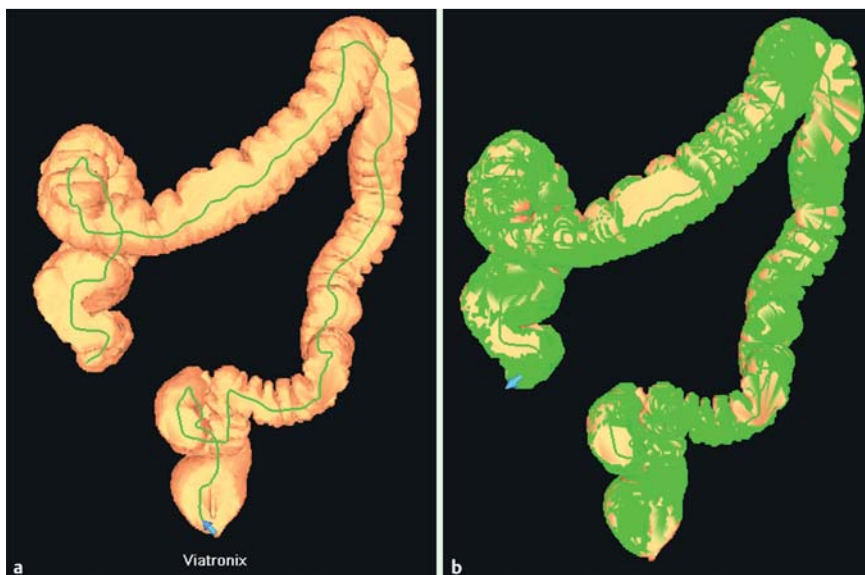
a Overview of the colon with centerline for navigation (green) automatically drawn by the CT colonography software. b Overview after unidirectional 3D-endoluminal flythrough facing the cecum, where the software had “painted” visualized areas green. Unseen areas remain beige.
